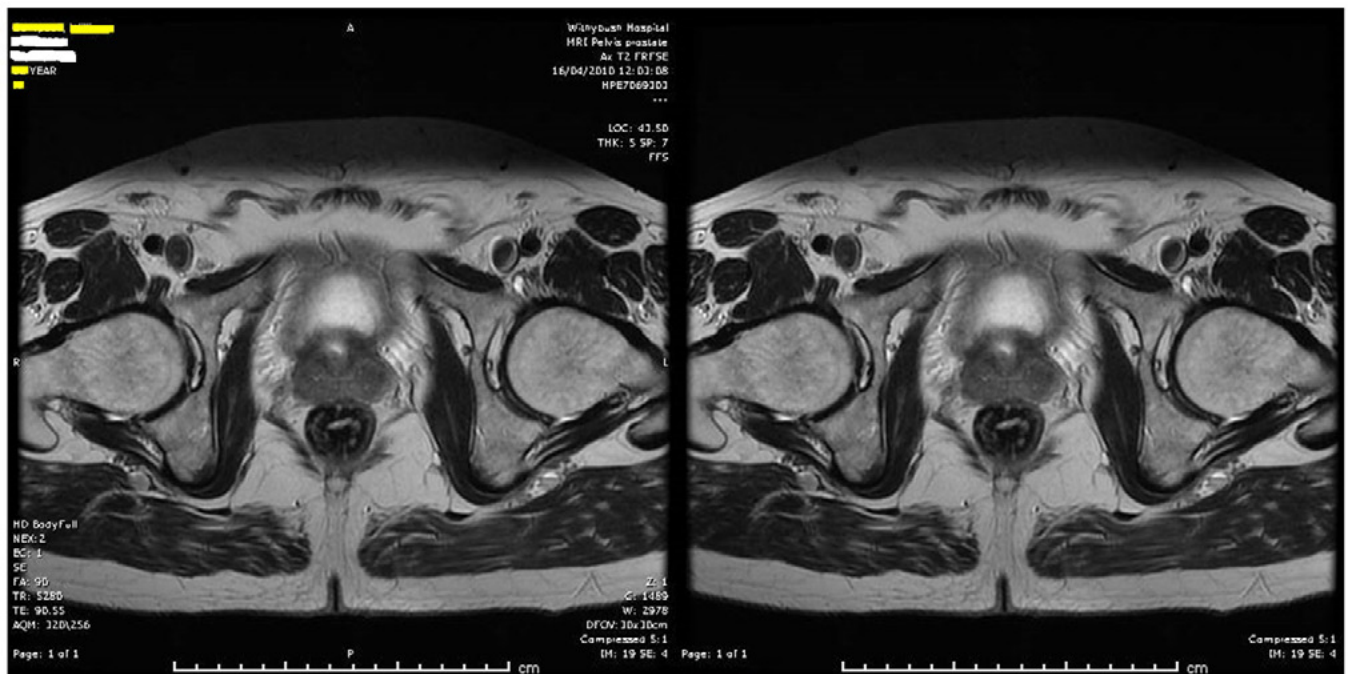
Example of an anonymized MRI scan image.
